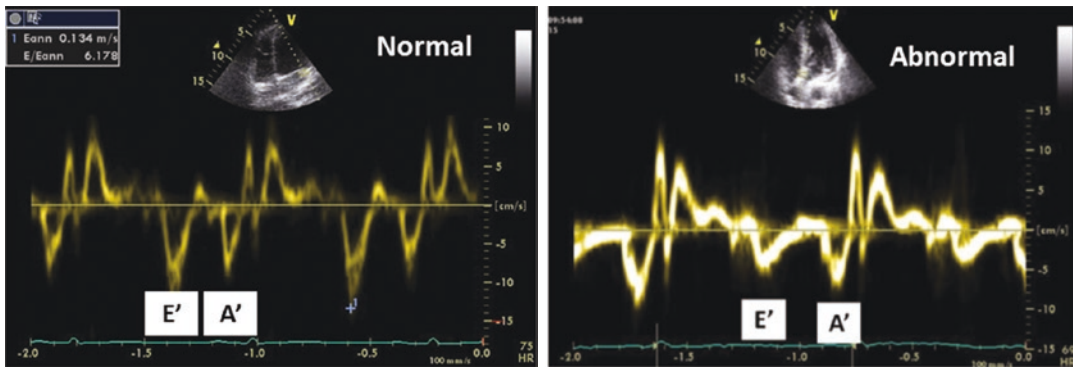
Mitral annulus velocities using Doppler Tissue Imaging (DTI). *E'* early diastolic velocity of mitral annulus, *A'* late diastolic velocity of mitral annulus
